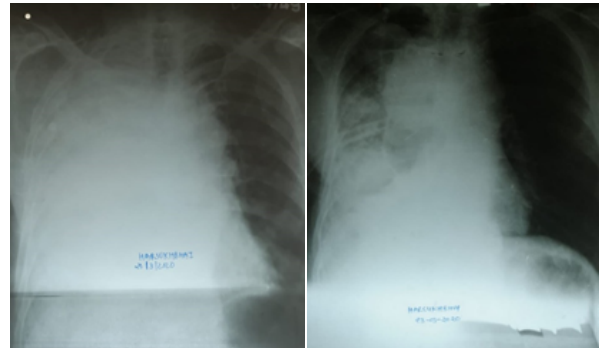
Chest X-ray PA view showing homogenous opacity on the right side involving all zones with obliteration of the costophrenic angle.
